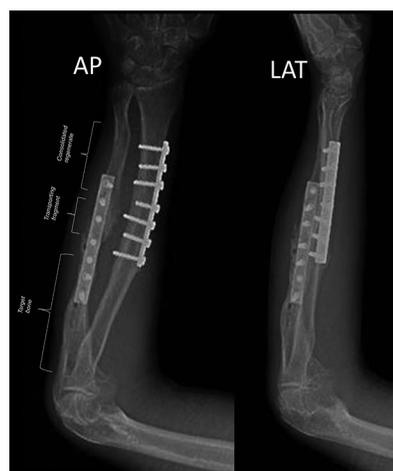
Following 138 days of fixator duration, fixator is removed from Patient 1's forearm after bone contact was achieved. Fixation of an internal plate with bone-grafting of the docking site was performed, ulnar defect was restored and solid osseous union was achieved, as seen in anteroposterior and lateral radiographs
